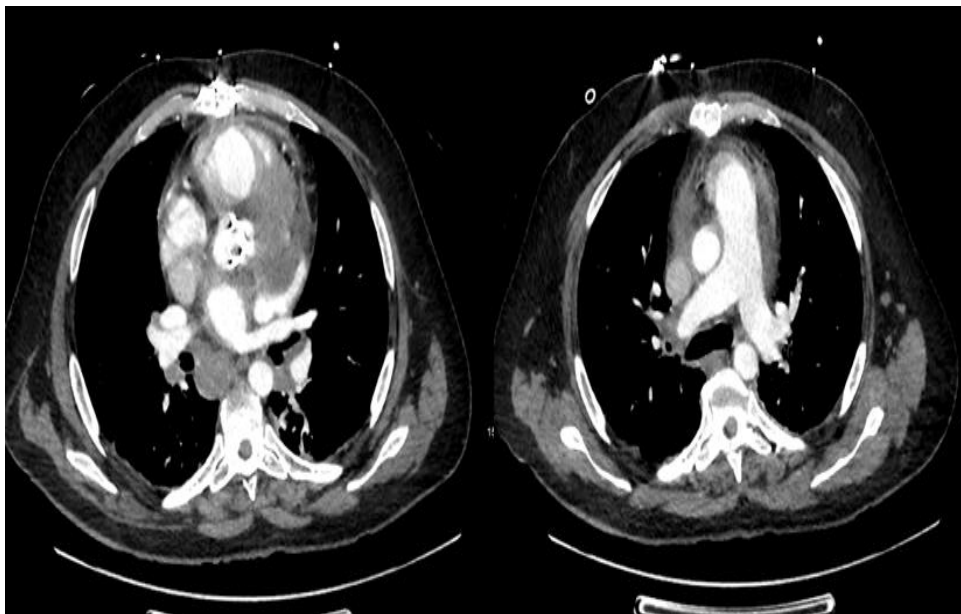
Post-operative thoracic CT scan: a stable appearance of the thrombosed false aneurysm
